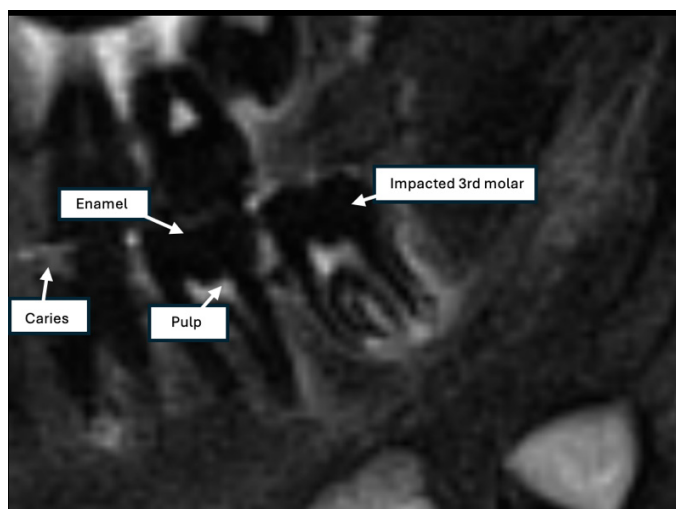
T2W SE MRI sagittal section showing dental structures. Note that peripheral area of the impacted 3rd molar is hyperintense compared to the normal bone and the impacted tooth is in close relation with inferior alveolar nerve.
